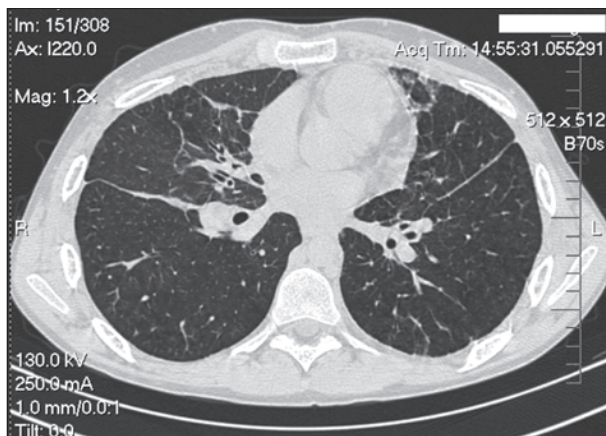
HRCT slice through the lower lung zone demonstrates diffuse bronchial wall thickening and marked dilatation of intrapulmonary branches of pulmonary veins. Smooth thickening of the interlobular septa is seen in some areas associated with areas of ground-glass opacity
